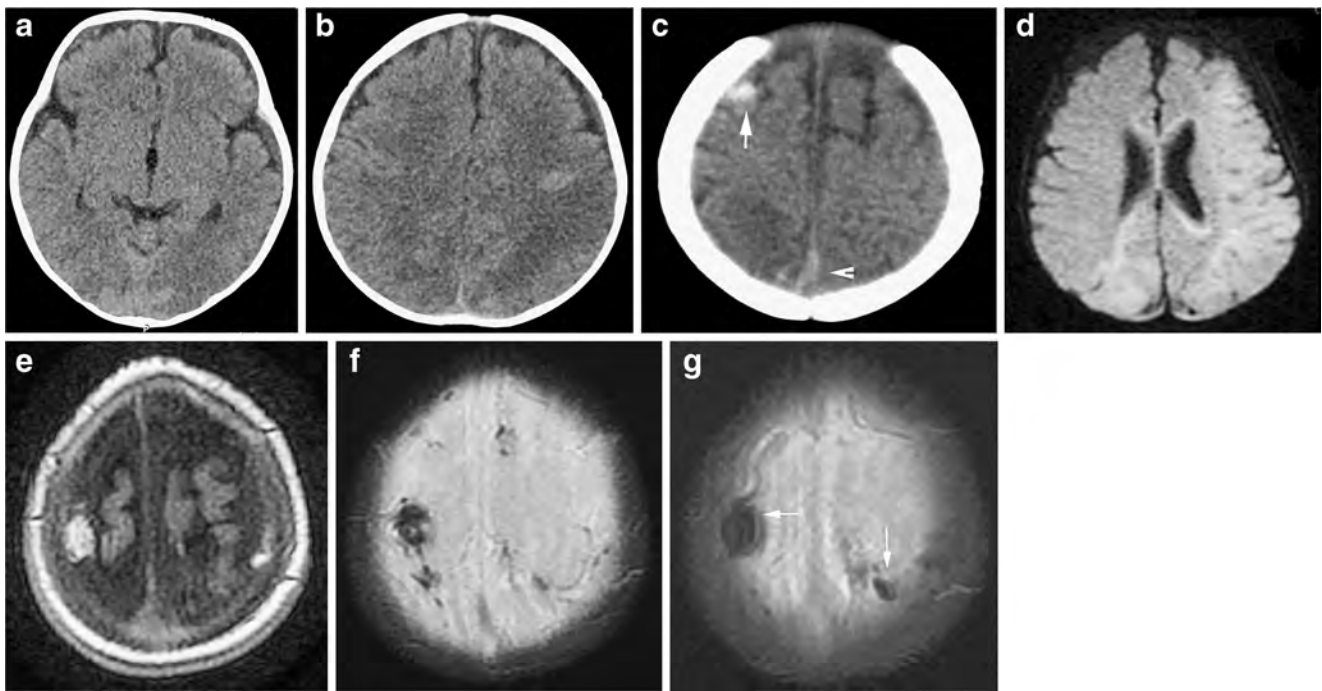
A 3-month-old boy who suffered abusive head trauma. a–c CT at admission shows thin frontotemporal subdural hematomas of heterogeneous low density and large parenchymal hypodensities with loss of gray/white matter contrast due to hypoxic-ischemic injuries (a, b). There is a hyperdense spot at the vertex on the right side (c, arrow) and mild hyperdensity in the interhemispheric fissure (c, arrowhead). d–g MRI
